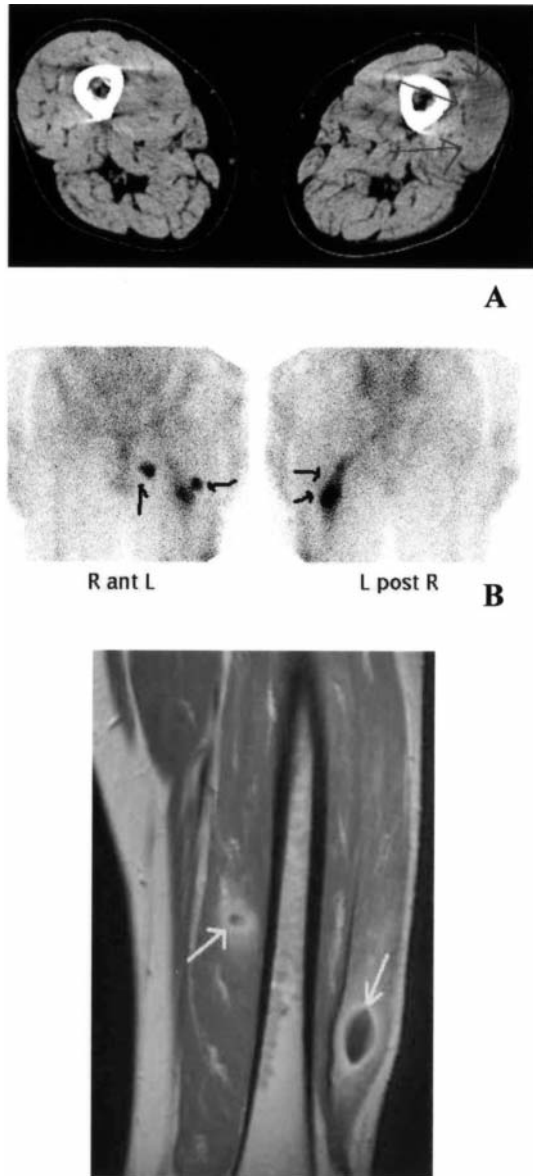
Computed tomography, Ga scintigraphy and magnetic resonance image of the left thigh. A: Computed tomographic scan on day 27 showing a low-density area in the left quadriceps femoris muscle (arrows). B: Ga scintigraphy on day 34 revealing abnormal uptake in the left thigh (arrows). C: T2-weighted magnetic resonance imaging on day 39 showing high signal intensity areas 2 cm and 4 cm in diameter in the left vastus medialis muscle and vastus lateralis muscle, respectively (arrows).
